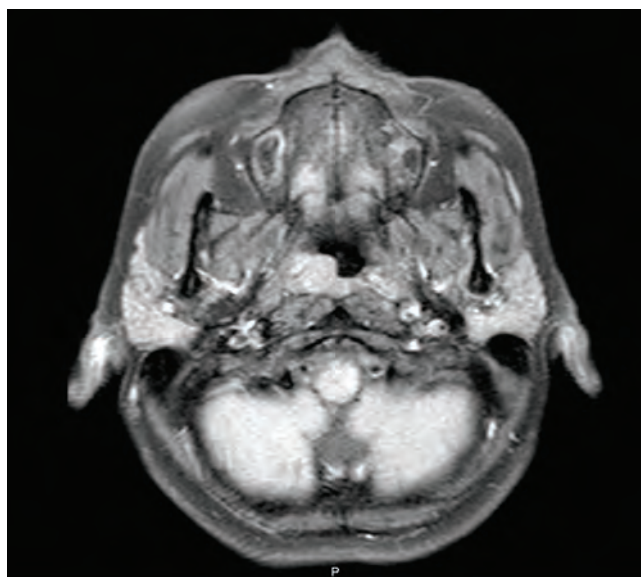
T1 axial slice MR image of the mass filling the right Rosenmüller fossa in the nasopharynx
